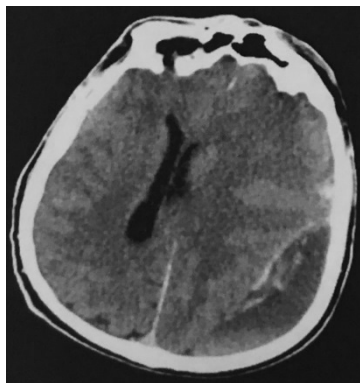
89 years old patient CT scan in axial plane showing left frontal-parietal CSH and a recent ischemic event localized left frontal-pole
